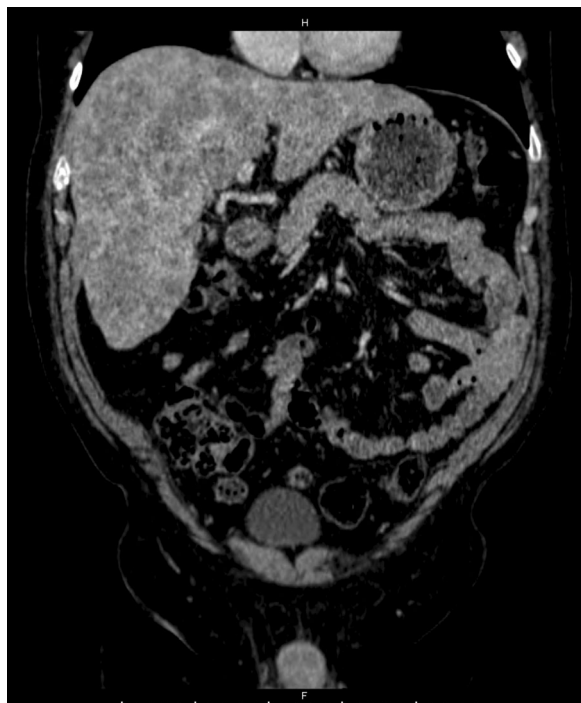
CT scan of the thorax and abdomen
